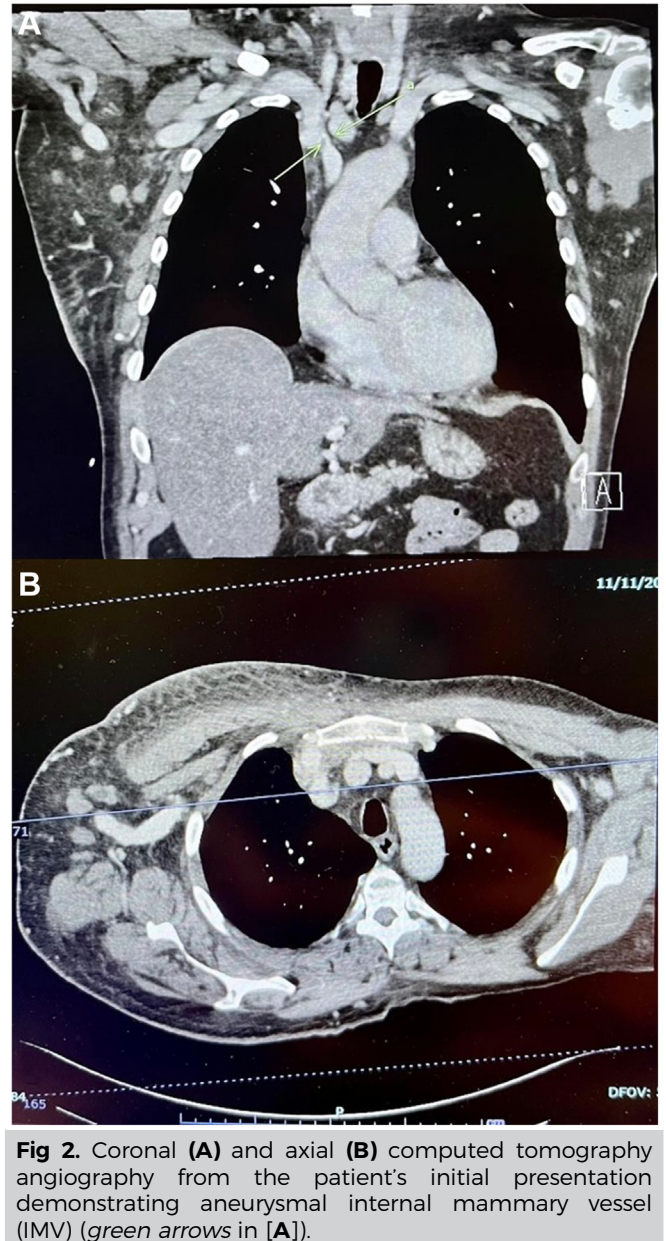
Coronal (A) and axial (B) computed tomography angiography from the patient's initial presentation demonstrating aneurysmal internal mammary vessel (IMV) (green arrows in [A]).
